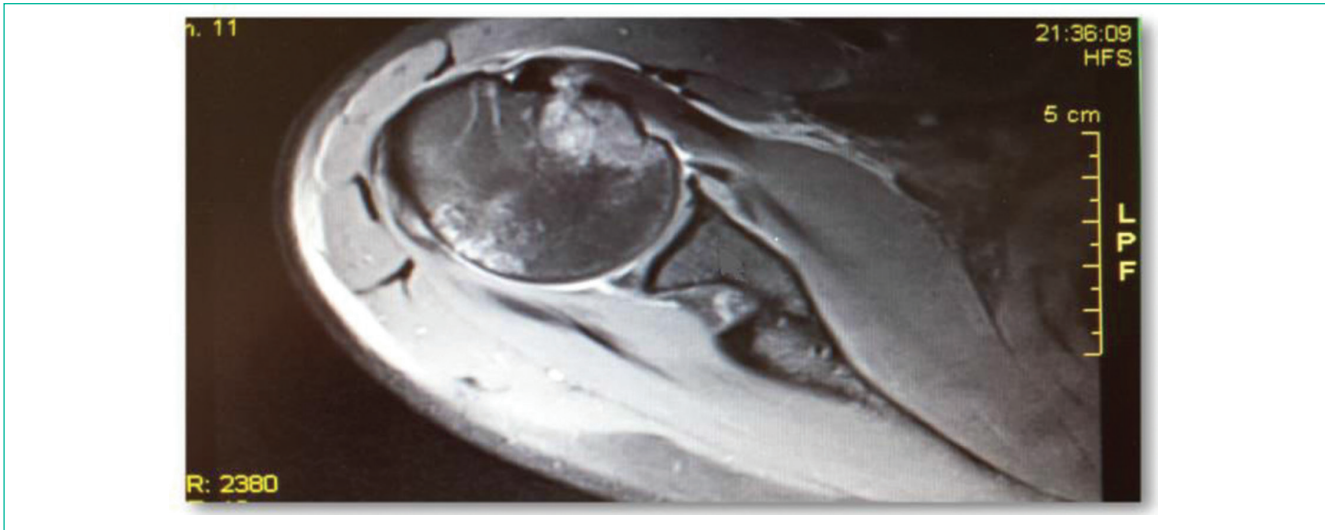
MRI of the shoulder (R).
